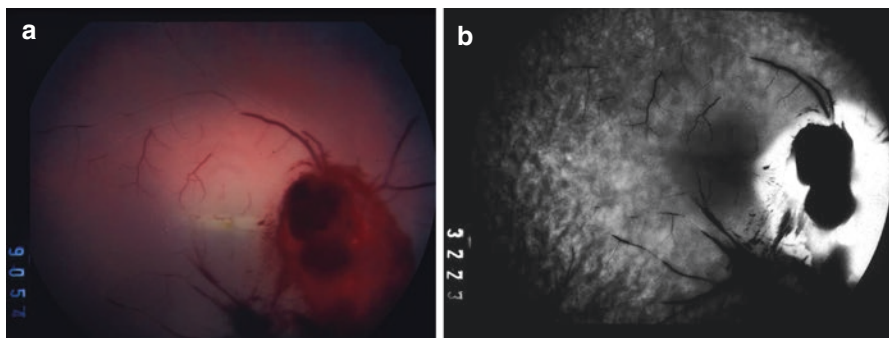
Color photograph (a) and fluorescein angiogram (right eye) (b) from a patient who sustained a relatively minor injury in that he was struck on the right side of his head while playing baseball. He immediately lost all vision in the right eye, and ocular findings were compatible with avulsion of his optic nerve. CT scanning was unable to absolutely document the findings
